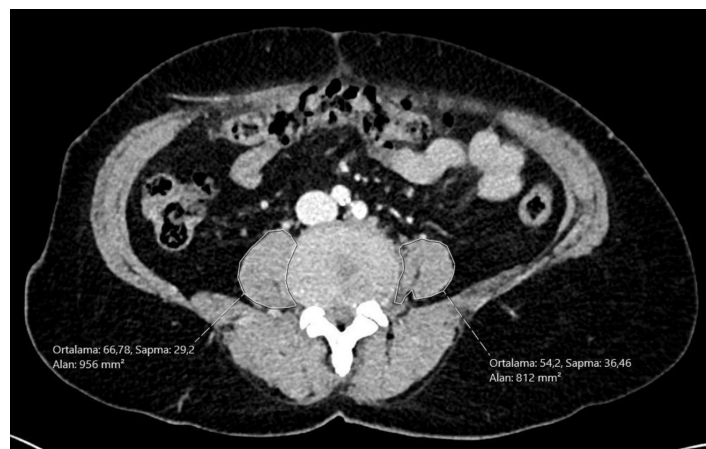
An example of how PSMAI is measured in axial CT images
